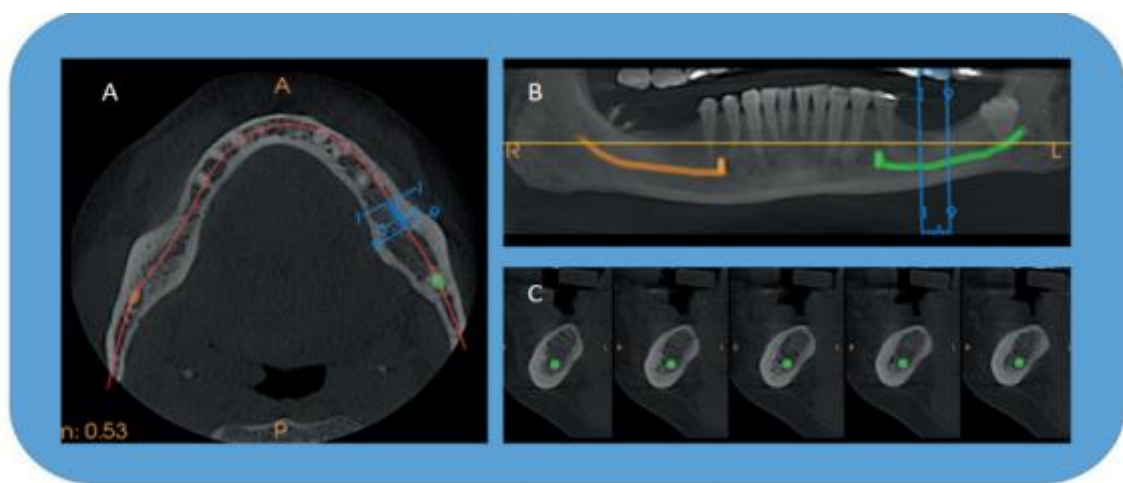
cbct scan of mandible
